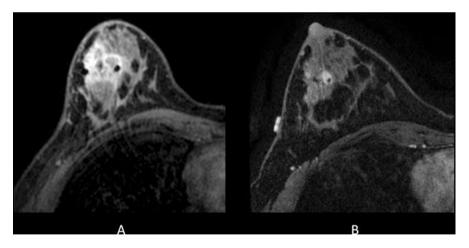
Thirty-one-year-old woman who presented with right breast 3 cm palpable lump. Ultrasound guided biopsy confirmed grade 3 invasive ductal carcinoma. At the time of biopsy, a suspicious axillary node was identified and a fine needle aspiration confirmed metastatic disease. The patient subsequently underwent breast MRI to determine the extent of disease. (a) Pretreatment MRI confirmed extensive disease in the right breast and several suspicious right axillary lymph nodes. The patient then underwent neoadjuvant chemotherapy. (b) Posttreatment MRI showed partial response to therapy
